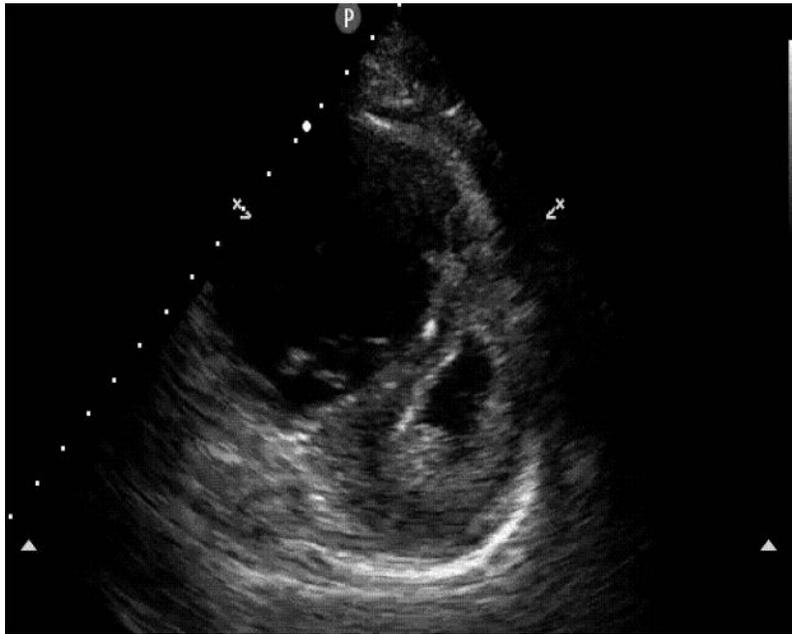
Parasternal short-axis (PSAX) with D-shaped septum.⁴
